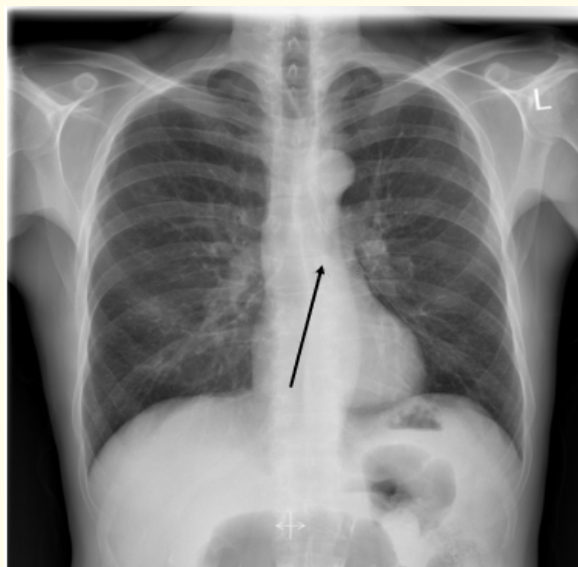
Posterior-anterior thorax X-ray.
